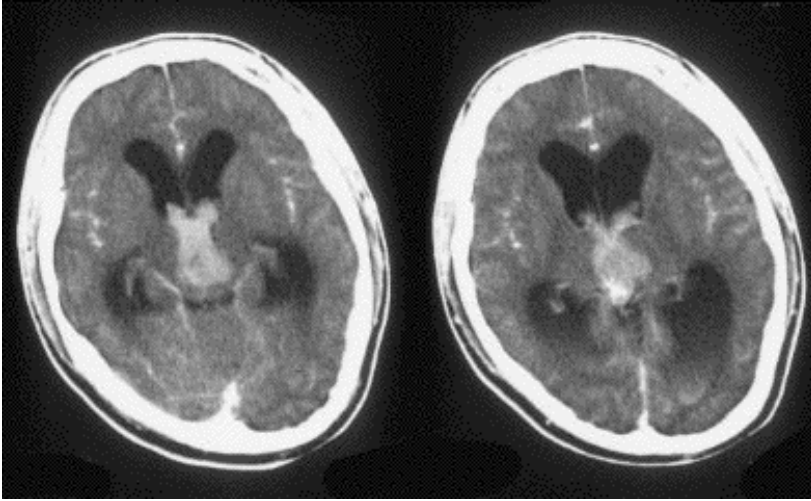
A 16-year-old boy who was admitted in a comatose state. CT scans show intraventricular hemorrhage with hydrocephalus. The level of beta-hCG was markedly elevated. The diagnosis of choriocarcinoma was confirmed by biopsy three weeks later.
